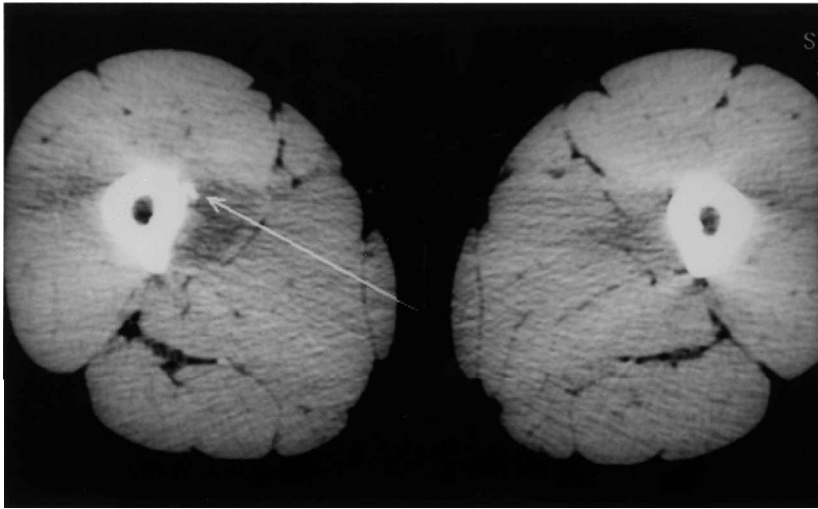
CT scan of the mid-femur shows a periosteal mass with a soft tissue component. A scalloping of the cortex is seen. The density of the medulla appears normal.
